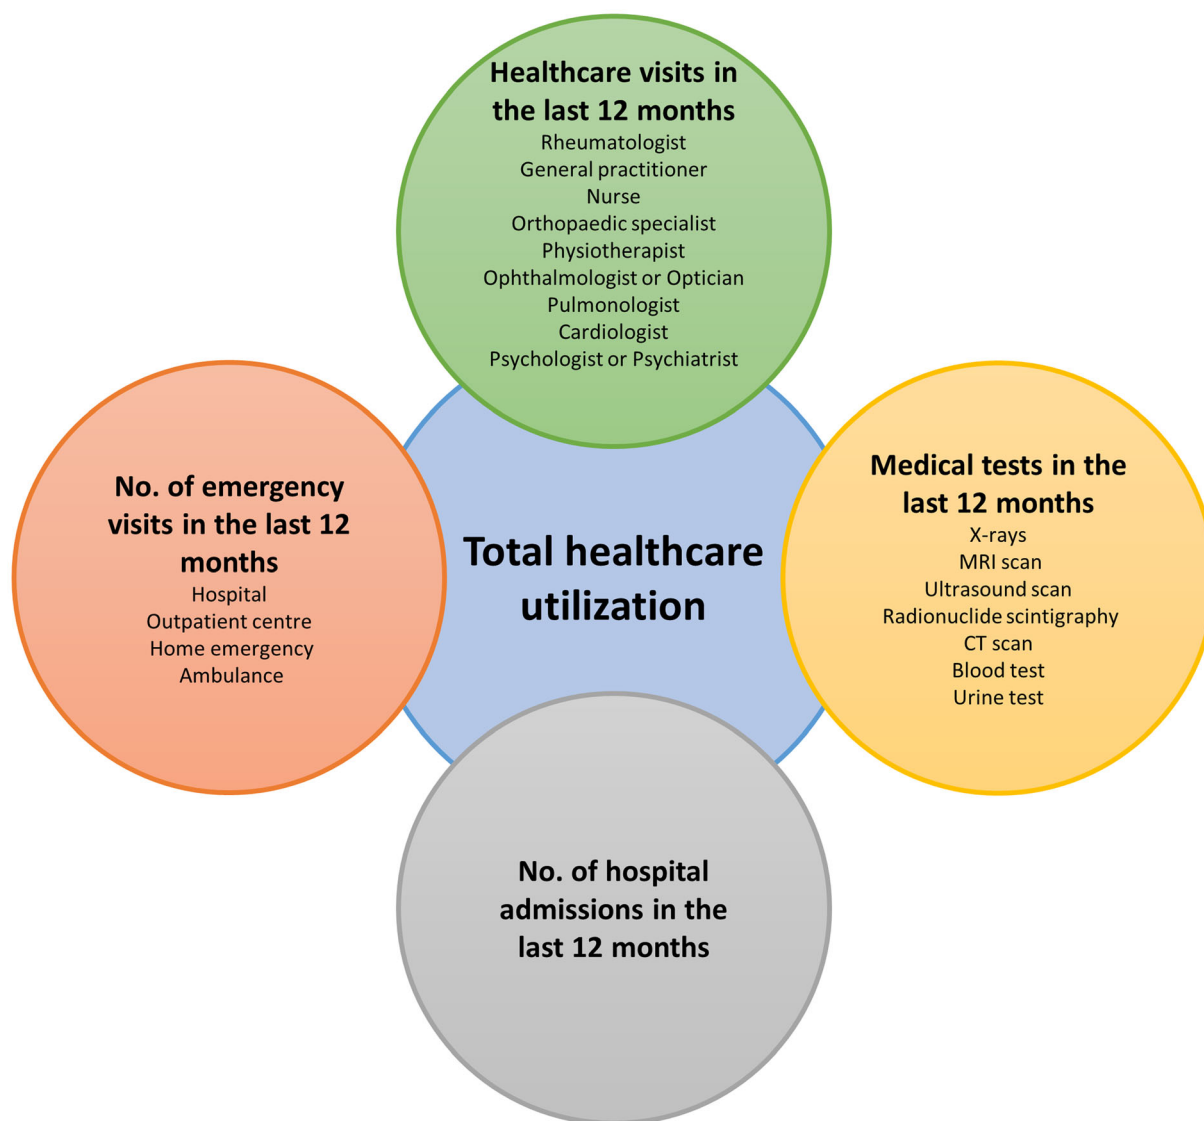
Total healthcare utilization by patients with axSpA. *MRI* magnetic resonance imaging, *CT* computed tomography
